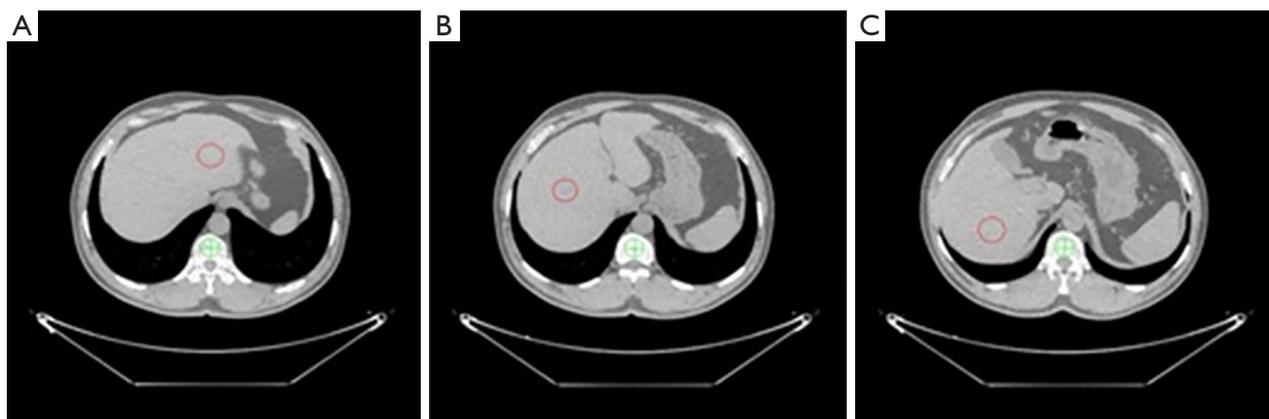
Measurement of liver fat content by QCT using Mindways liver fat module. The slice in the middle of the L2 is chosen, 3 region of interests (ROIs) (shown in red circle) are measured, with one in the left lobe of the liver (A) and two in the right lobe (B,C). The liver fat content in % is shown and saved in the database. The average of 3 ROIs is the value for this subject. QCT, quantitative computed tomography.
